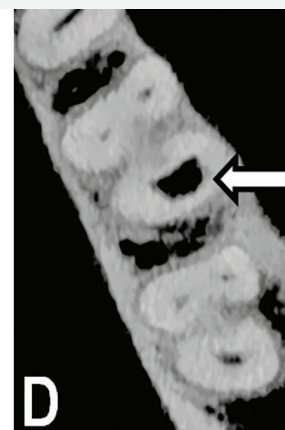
Preoperative axial CBCT showing the size of the IRR at the level of the middle third of the distal canal (arrow)
